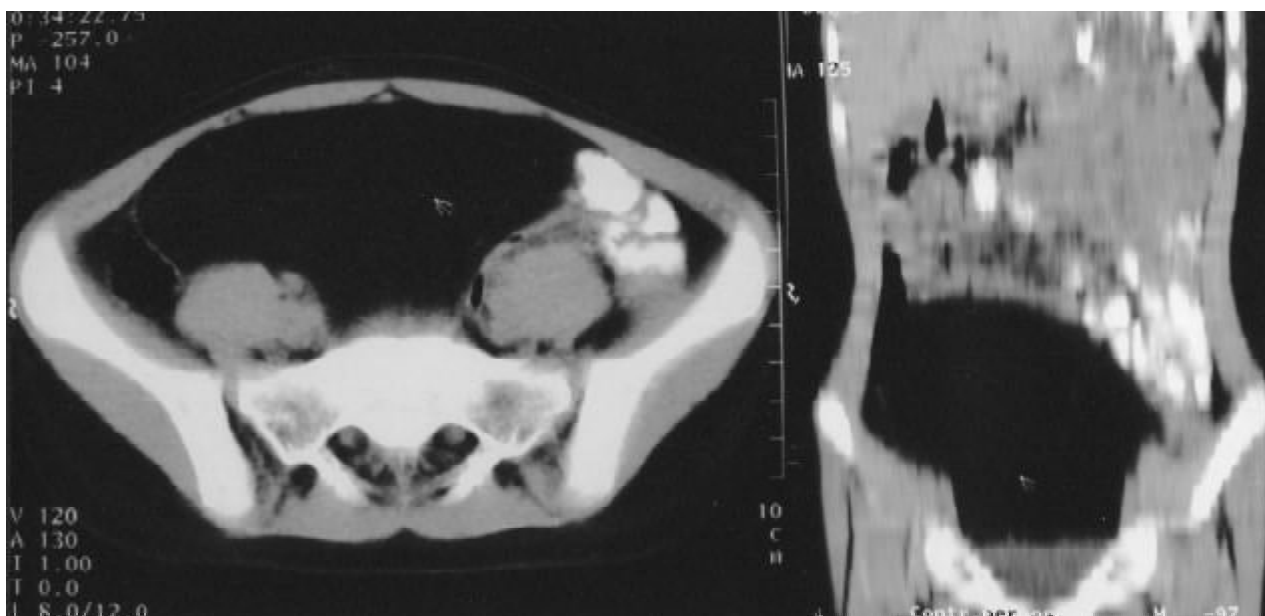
CT showing intraperitoneal encapsulated mass
